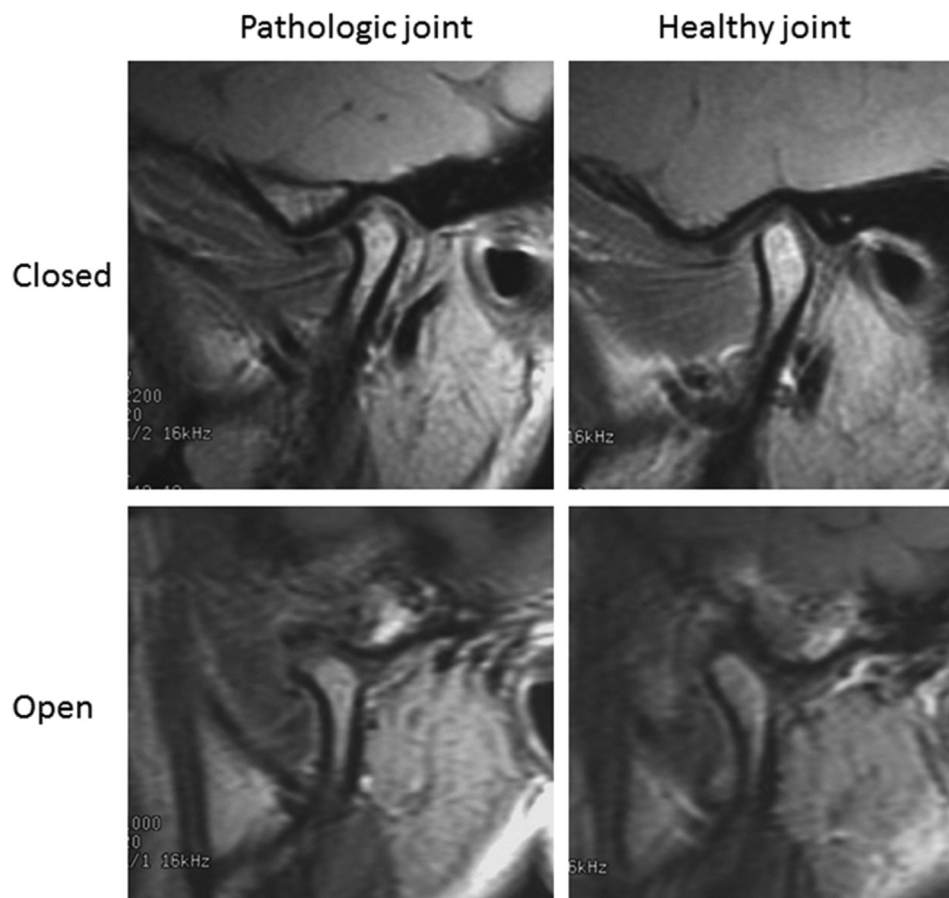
Clinical MR images of a patient TMJ with unilateral anterior disc displacement sectioned in the direction perpendicular to the condylar axis.
